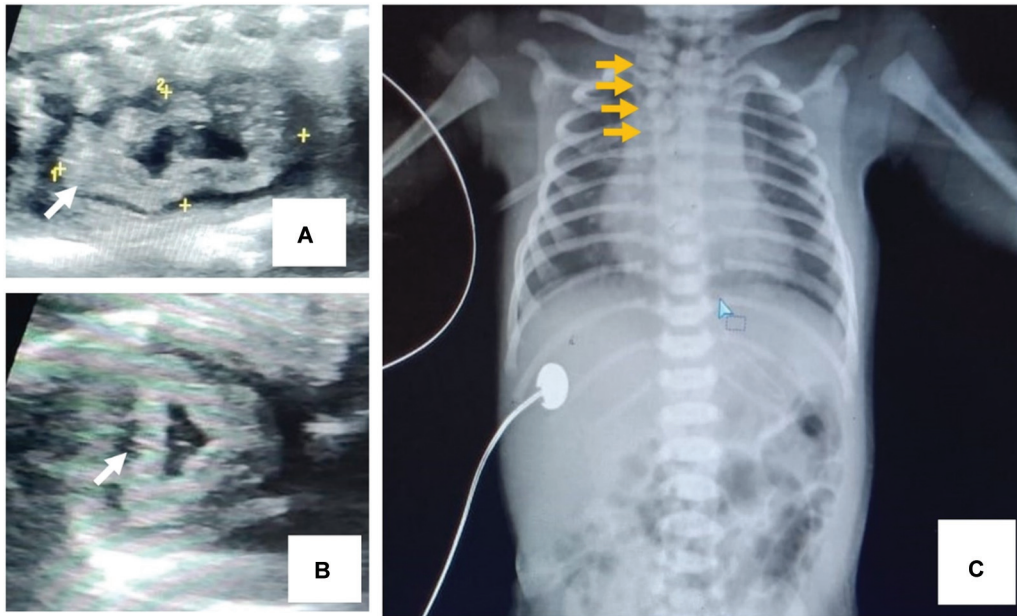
(A) Neonatal chest ultrasound. (A) Sagittal section and (B) axial section showing collapsed cyst (white arrow) measuring 25.3 × 11.3 mm. (C) Neonatal infantogram showing clear lung spaces and hemivertebrae in thoracic segment (yellow arrows).
